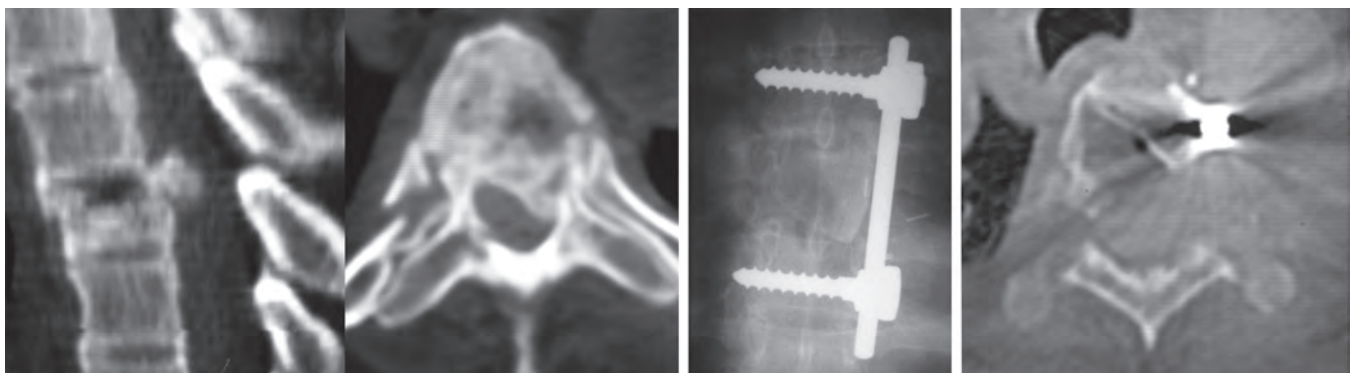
Sagittal and axial CT of the same patient as in Fig. 4 with T5 burst fracture (left). Transthoracic corpectomy, anterior stabilisation and iliac autograft placement were done (middle). The smaller size of the thoracic body permits only one screw placement in each body but this proves sufficient. The vertical rod also serves to prevent lateral graft extrusion. The graft is impacted with the screws in distraction for restoration of height. Once seated, the graft is placed under compression. Note the canal decompression in the postoperative axial CT (right)
